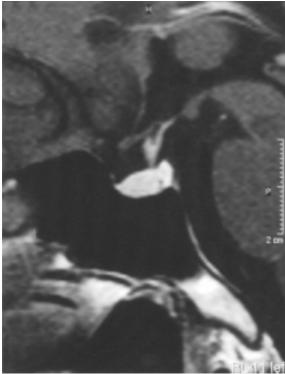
Repeat contrast-enhanced TI-W MR image taken in November 2001 shows the same lesion without progression.
